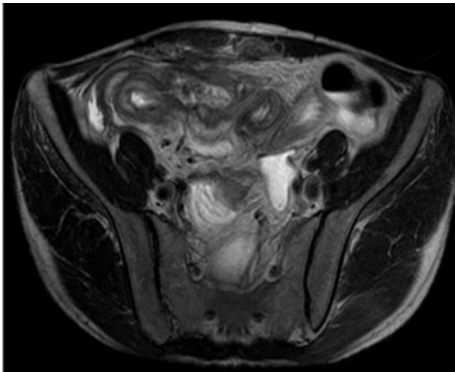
Fat-saturated axial T2-weighted sequence: parietal intramural edema
